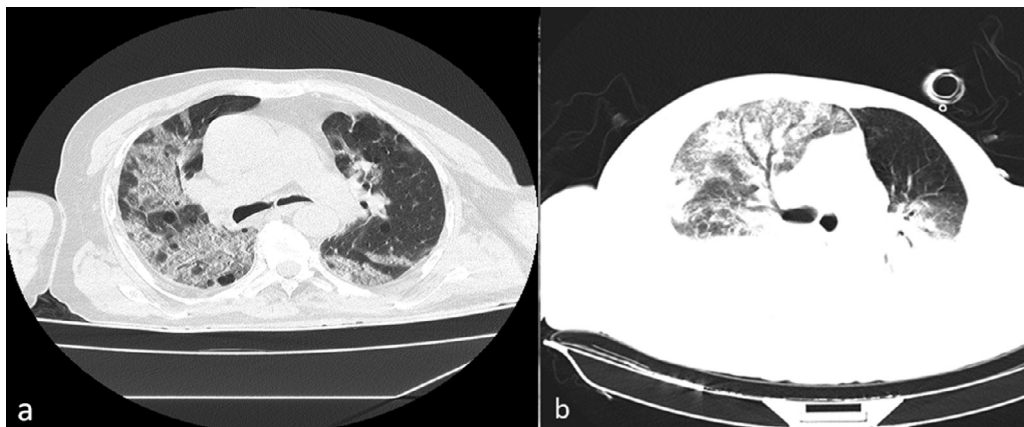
Typical Computed Tomography Findings of CCHF and COVID-19 a-Ground-glass opacities, consolidation, crazy-paving pattern, and air bubbles in COVID-19 b-Ground-glass opacities, consolidation with air bronchograms, and bilateral pleural effusion in CCHF.
